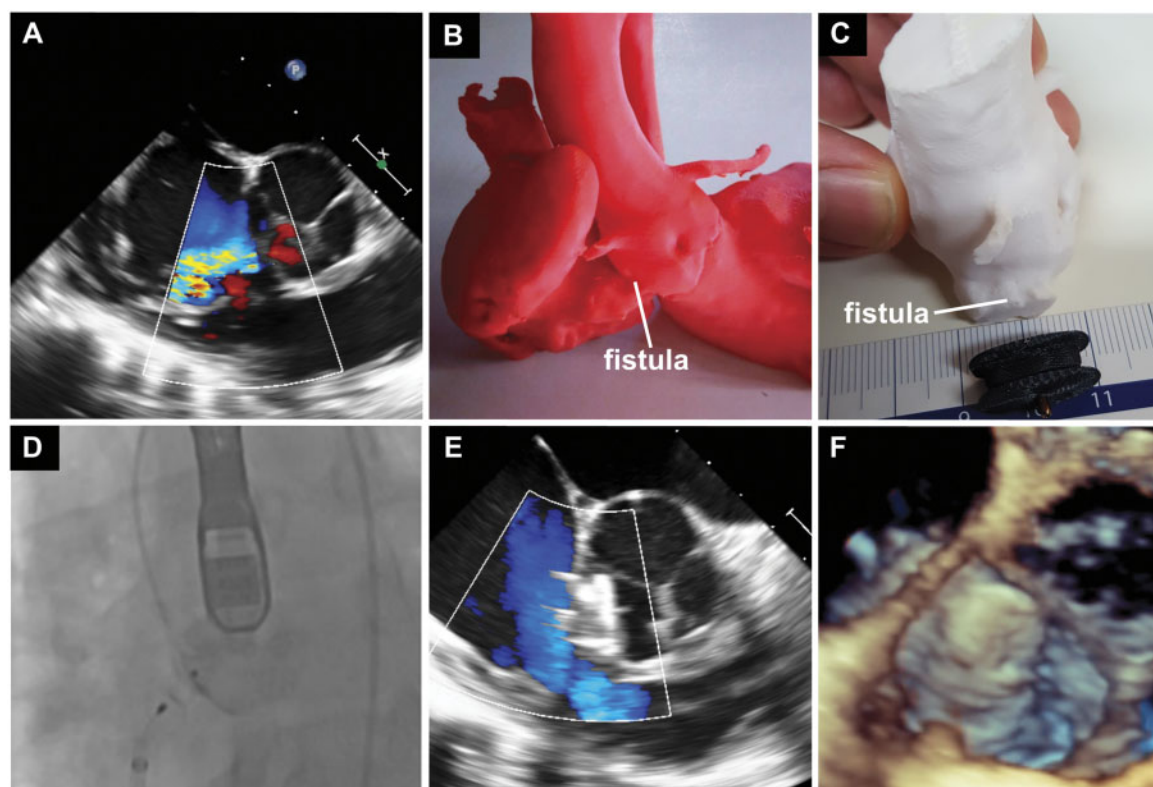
(A) TOE short axis at the aortic root demonstrating the fistula with colour-flow Doppler. (B) Three-dimensional printed model highlighting the position of the fistula between the right coronary cusp and right atrium, the right ventricle has been removed. (C) Three-dimensional model of the aortic root with the fistula sized next to an Amplatzer Vascular Plug III. (D) Fluoroscopic view confirming successful vascular plug implantation. (E) TOE short axis at the aortic root with colour-flow Doppler confirming obliteration of the fistula. (F) Three-dimensional TOE demonstrating successful implantation of the Amplatzer Vascular Plug III.
